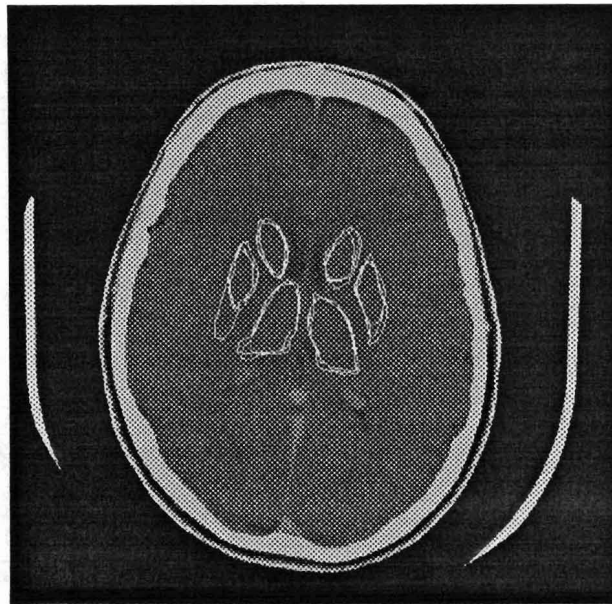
Typical example showing intra-observer variability. The three readings of the same expert were superimposed on the corresponding CT slice.
